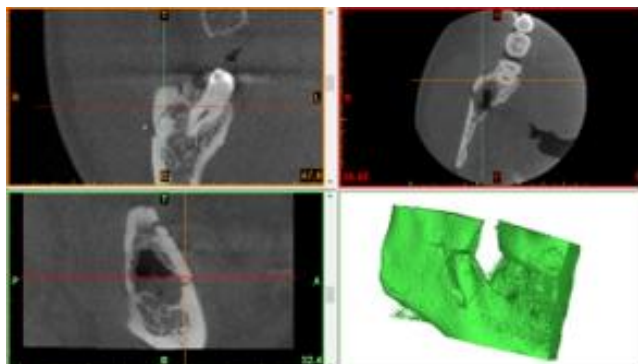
Immediate postoperative CBCTs radiograph
